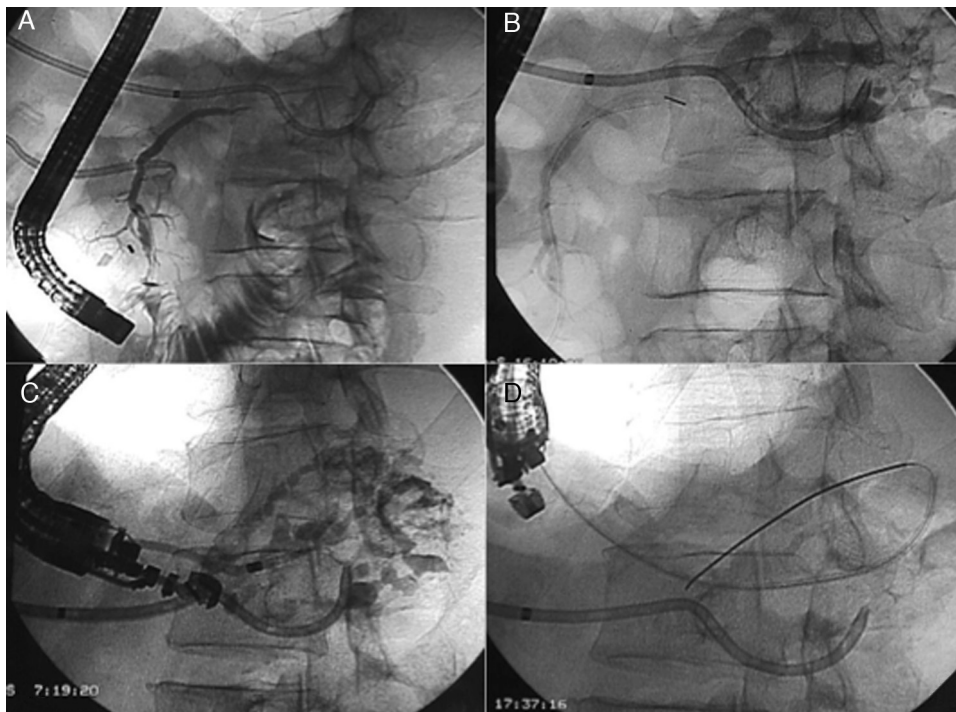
(A and B) Endoscopic retrograde pancreatography (ERCP): (A) Duct of Wirsung with complete transection in juxta-cephalic body with the head of the duct opacified, and no fill in body and tail. (B) Endoscopic catheter tip (sphincterometer) in the transection. Opacification of residual collection and Wirsung duct in the tail via percutaneous catheter. (C and D) Opacification of residual collection and Wirsung duct in the tail via the percutaneous catheter. (C and D) Endosonographic pancreatography (ESCP) via transgastric puncture. (C) Injection of contrast through a dilator introduced using transgastric Seldinger up to the duct of Wirsung in the tail. (D) Plastic pancreatogastric prosthesis, on guide (pancreatico-gastrostomy).
